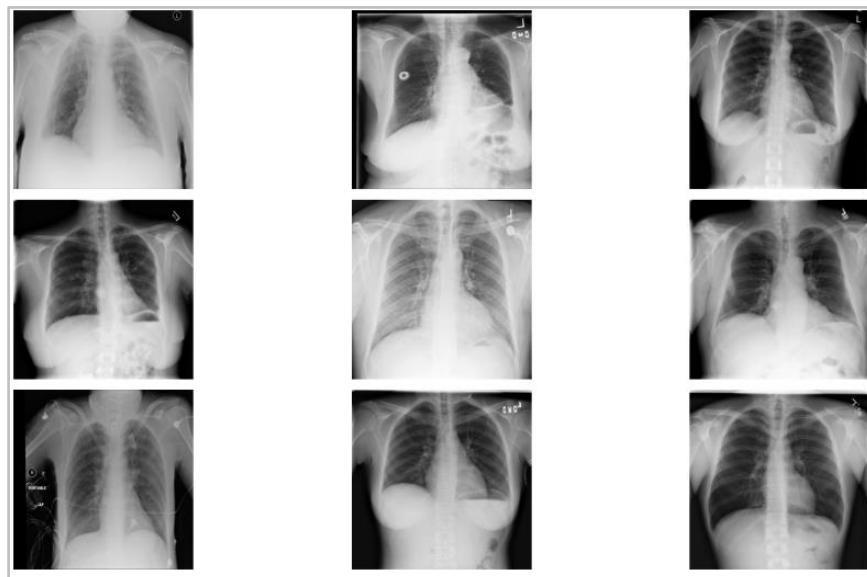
A chest x-ray identifies a lung mass.
